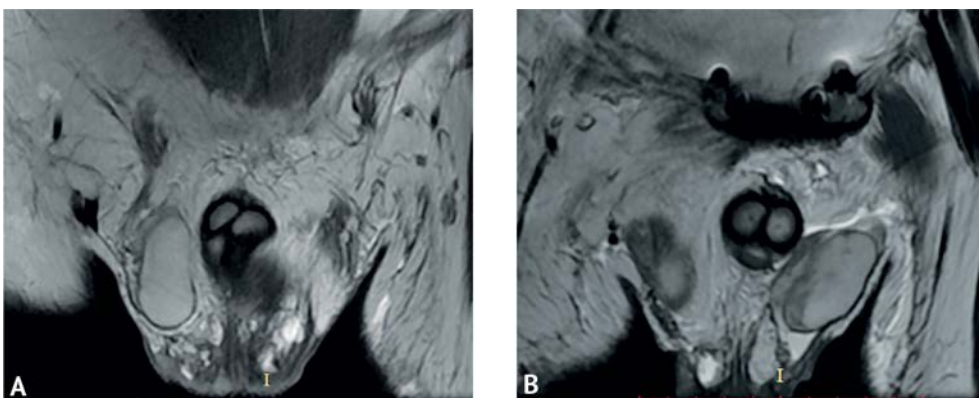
Magnetic resonance imaging of the scrotum by frontal (coronal) section with visualization of the right testicle (A); with visualization of the left testicle (B)
